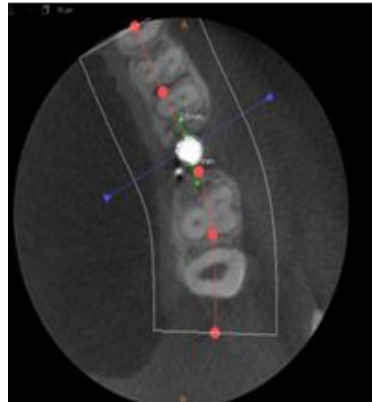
Pre-operative evaluation of linear measurement of distance of the proposed implant from the buccal and lingual cortices at the crestal level by software analysis of CBCT scan.
